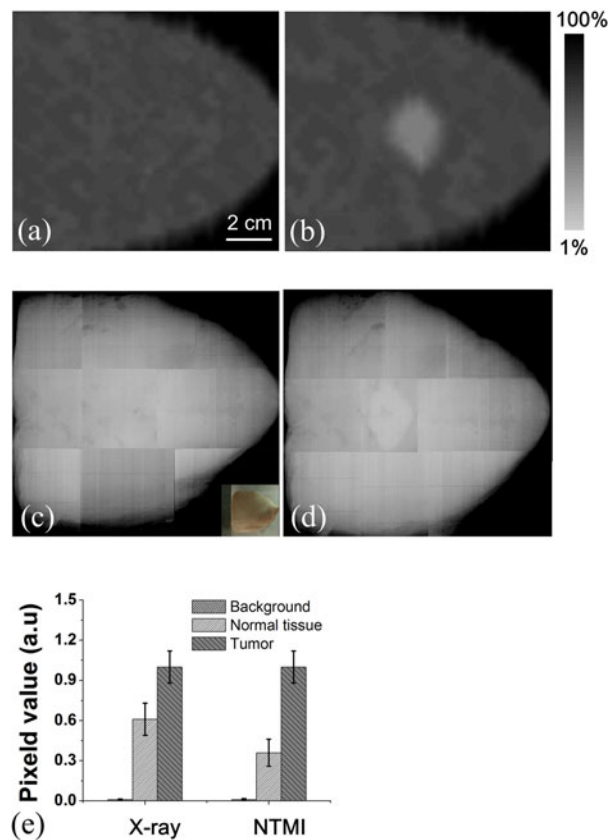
NTMI of the excised breast of ewe. (a) and (b) The breast of ewe without and with an excised breast tumor. (c) and (d) X-ray images responding to (a) and (b). (e) The normalized image contrast between tumor, normal tissue and background.
